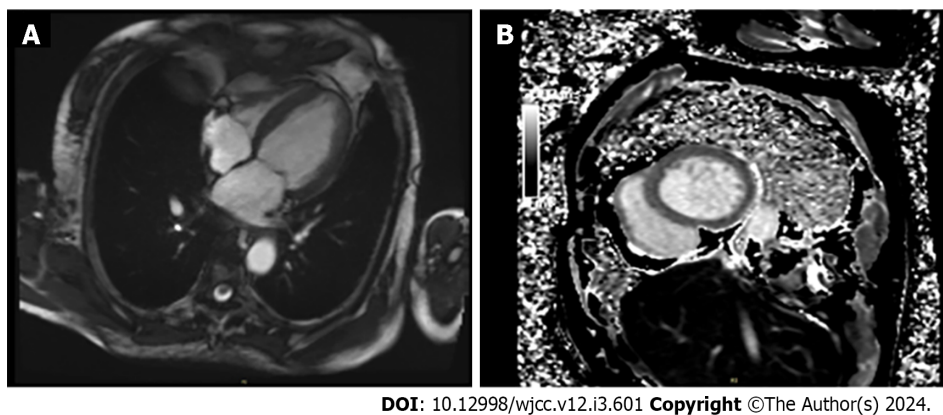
Cardiac magnetic resonance imaging. A: The four-chamber view showed an enlarged left atrium and left ventricle; B: Linear enhancement lesions was found in the middle layer of the cardiac septal myocardium.
